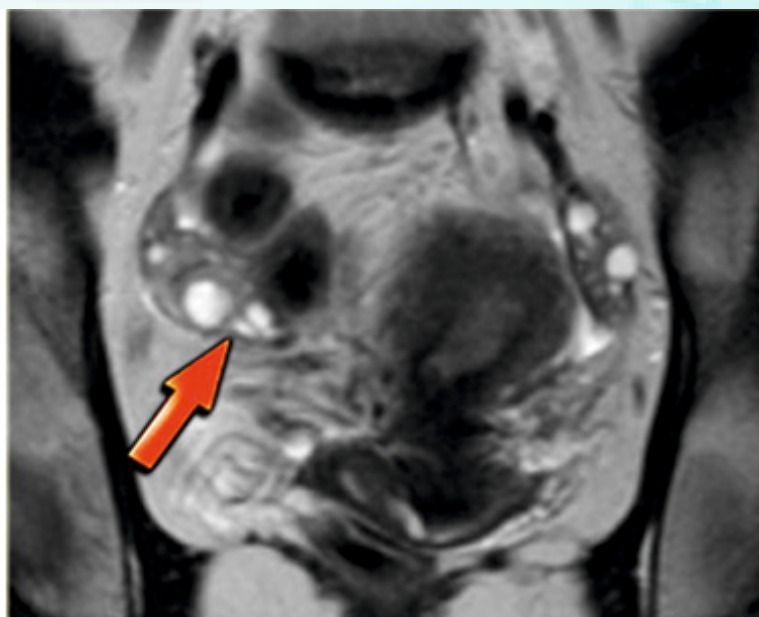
Superficial endometriosis on MRI
